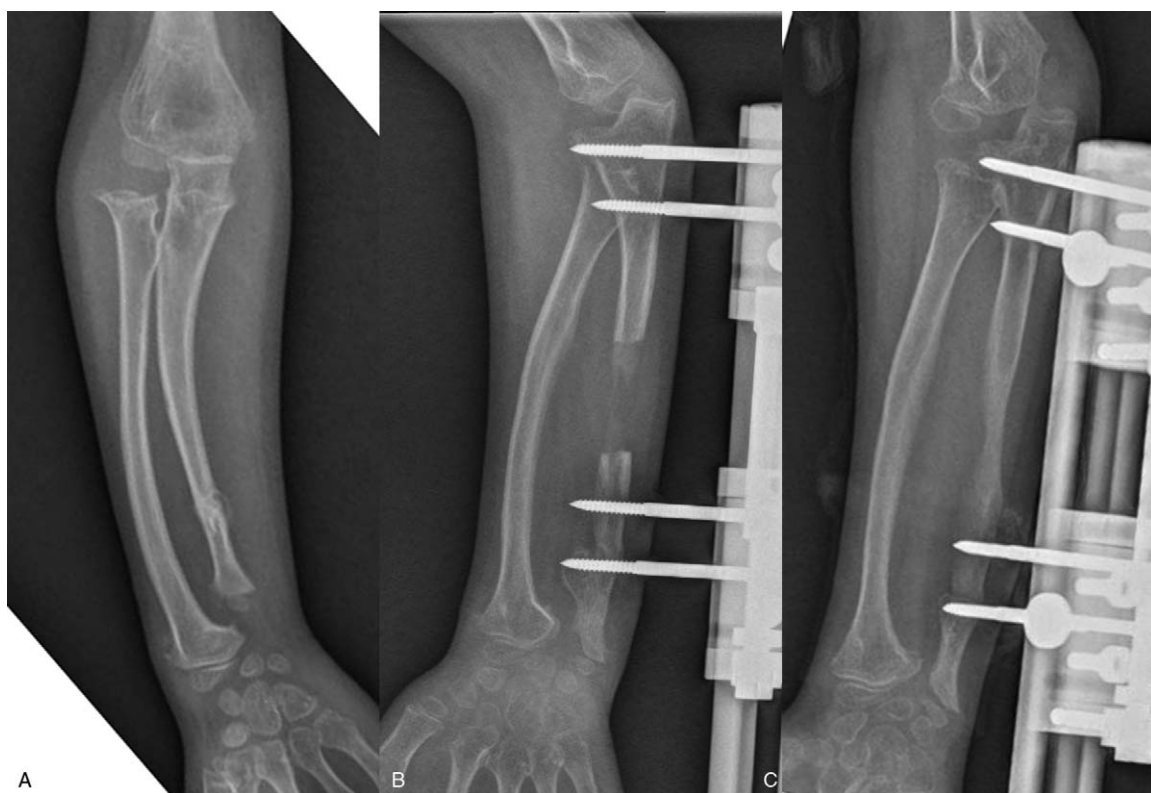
(a) A 9.7-year-old boy with Masada type I forearm deformity; he had a BMI of 14.1 kg/m^2 which was below the 50th percentile for children in his age range. (b) The ulna was gradual lengthened by a monolateral external fixator, radiograph showed lucent intermediate-density callus figure when 3.4 cm was gained. (c) Concave shape of regenerate bone was observed nearly 8 months after surgery; the bone healing index was 68.5 days/cm. BMI=body mass index.
